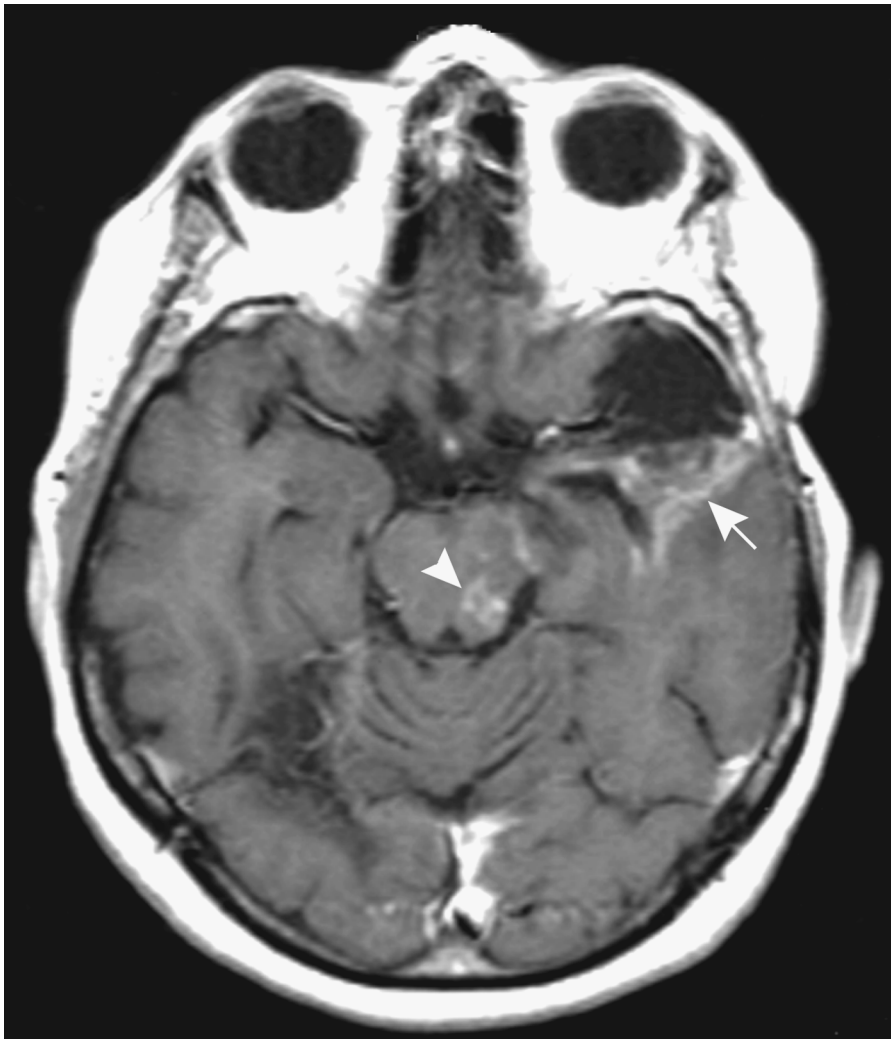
Post-contrast axial T₁-weighted MR image. Irregular enhancing lesions (arrow) posterior to the surgical cavity within the left temporal lobe and in the midbrain (arrowhead) were proved to be radiation necrosis at autopsy. The patient was status postsurgery with accelerated radiation therapy and chemotherapy for an anaplastic astrocytoma.
